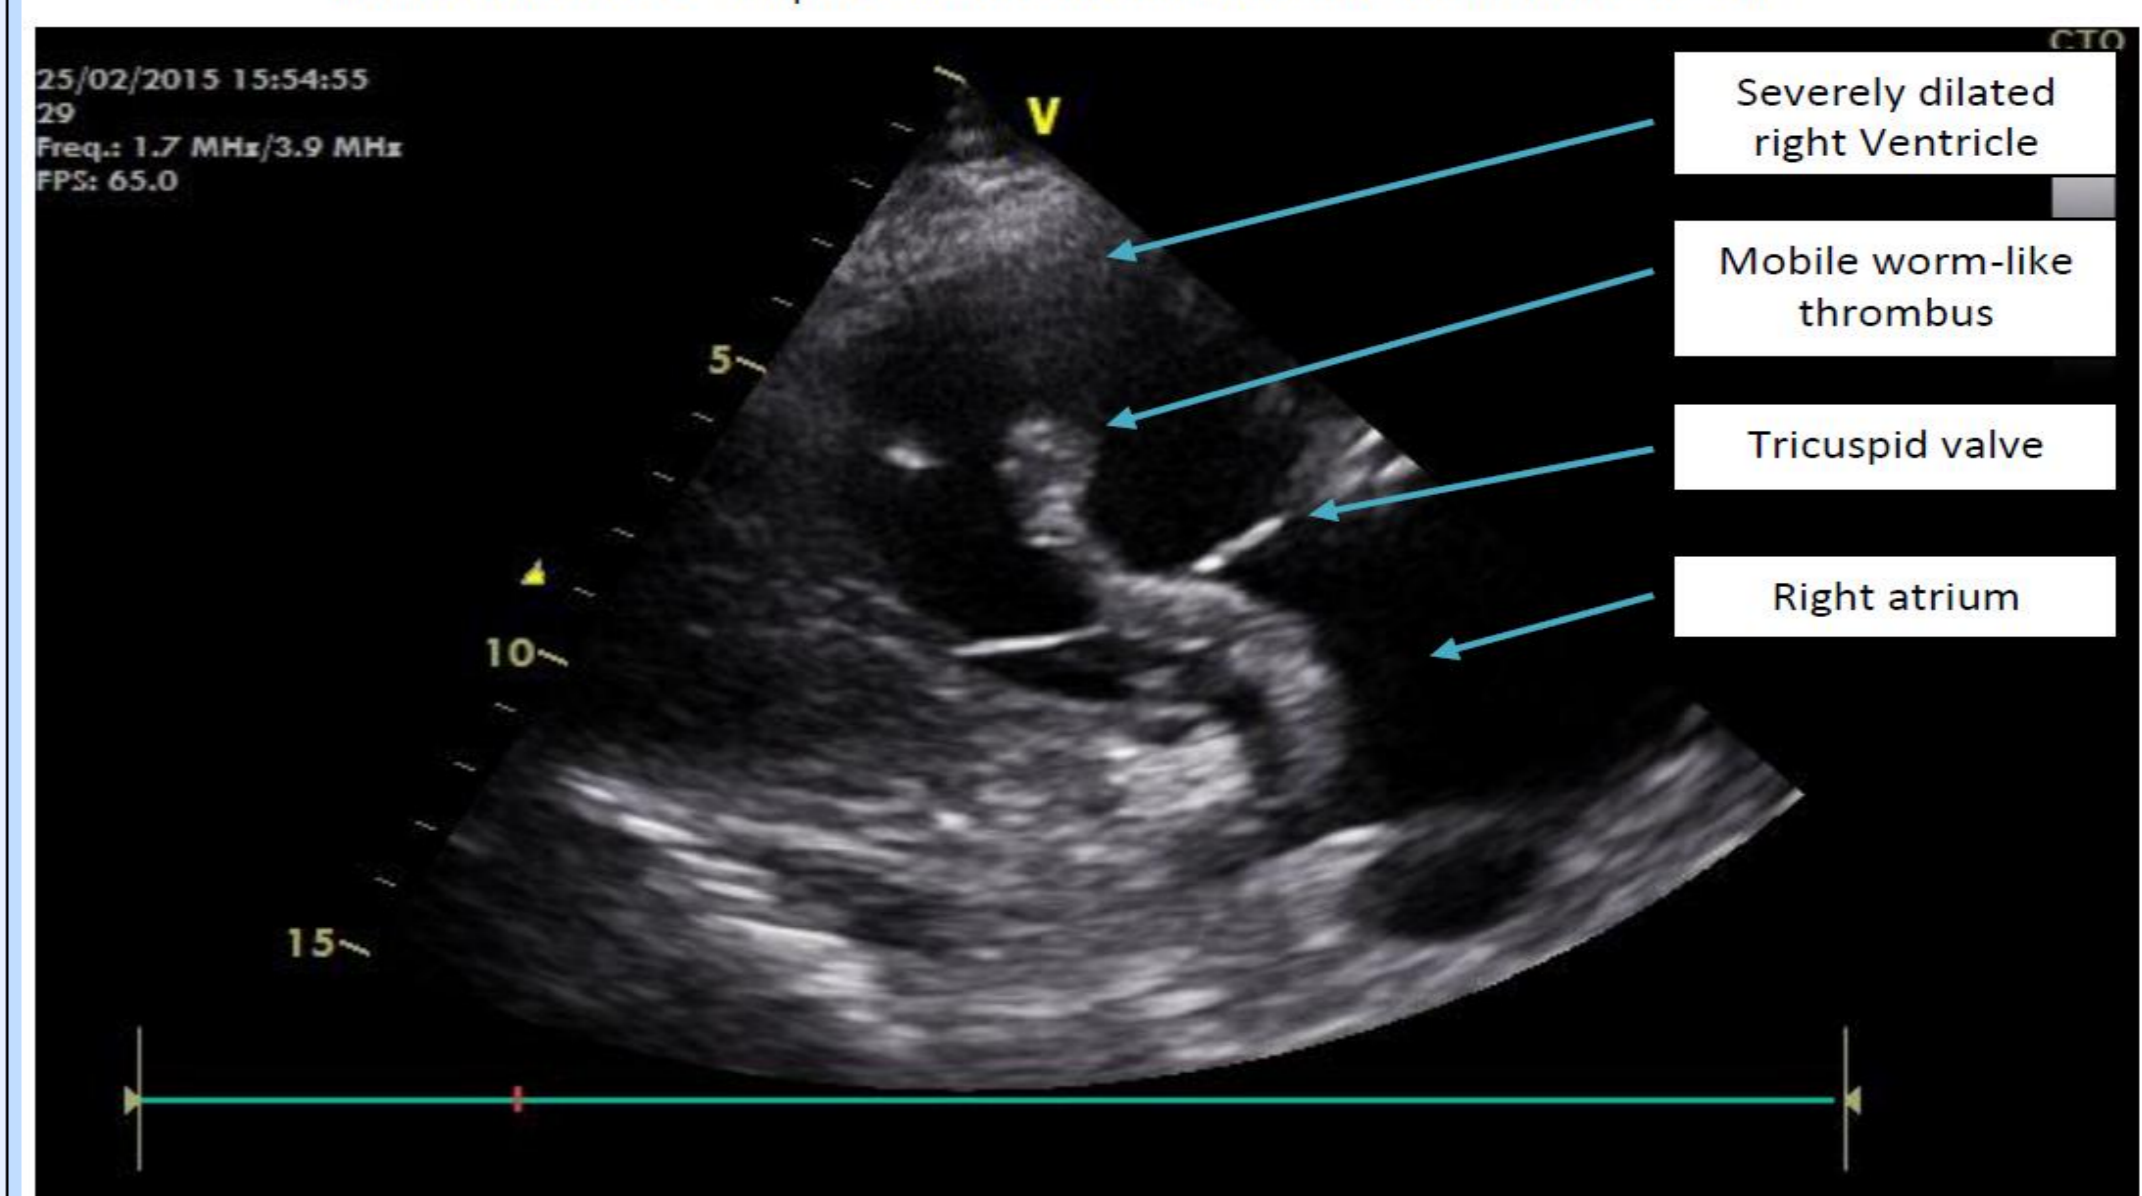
Trans-thoracic echocardiogram: Right ventricular inflow view showing mobile thrombus transversing the tricuspid valve into the right ventricle.
